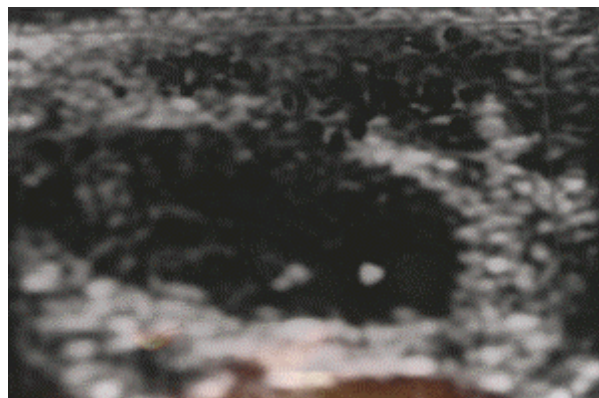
Scrotal Ultrasound demonstrating normal testis with significant subcutaneous edema in scrotal wall.
